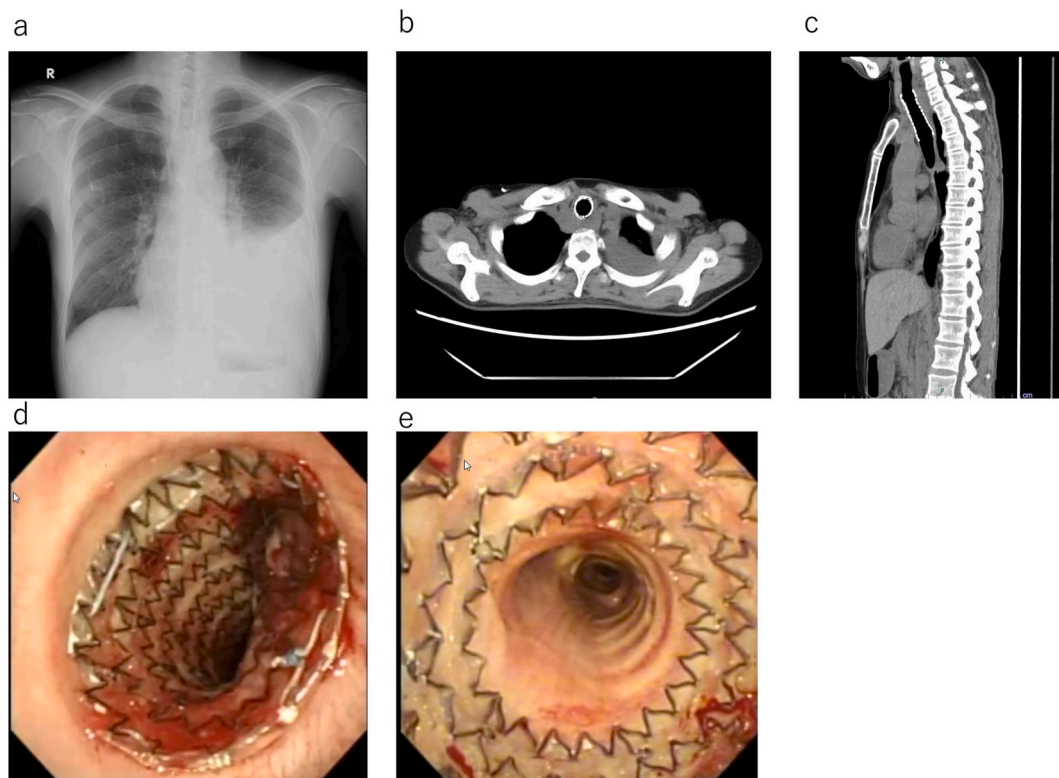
Chest radiography, computed tomography (CT), and endoscopic images obtained after the stent was placed. a. The stent had expanded sufficiently in the trachea. b. Horizontal section view of chest CT image. b. Sagittal section view. Chest CT revealed that the stent had expanded adequately and that the airway was patent. d. Endoscopic view, proximal view. e. Distal view. The stent had expanded sufficiently in the trachea.
